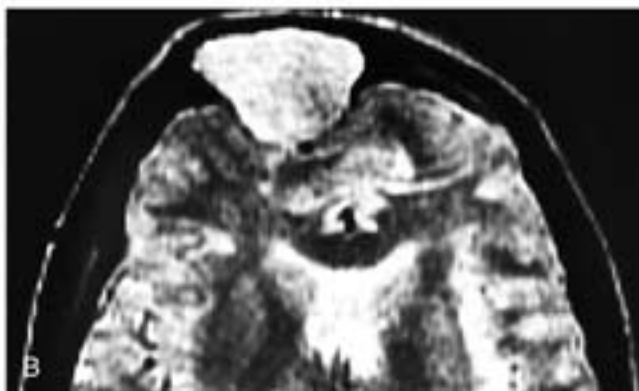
Sagittal T1-weighted (A) and axial T2-weighted (B) images show an expansile mass in the right frontal sinus that extends intracranially. The mass has low to intermediate, slightly nonhomogeneous signal intensity in A and high signal intensity in B. This patient had a frontal sinus meningioma.
